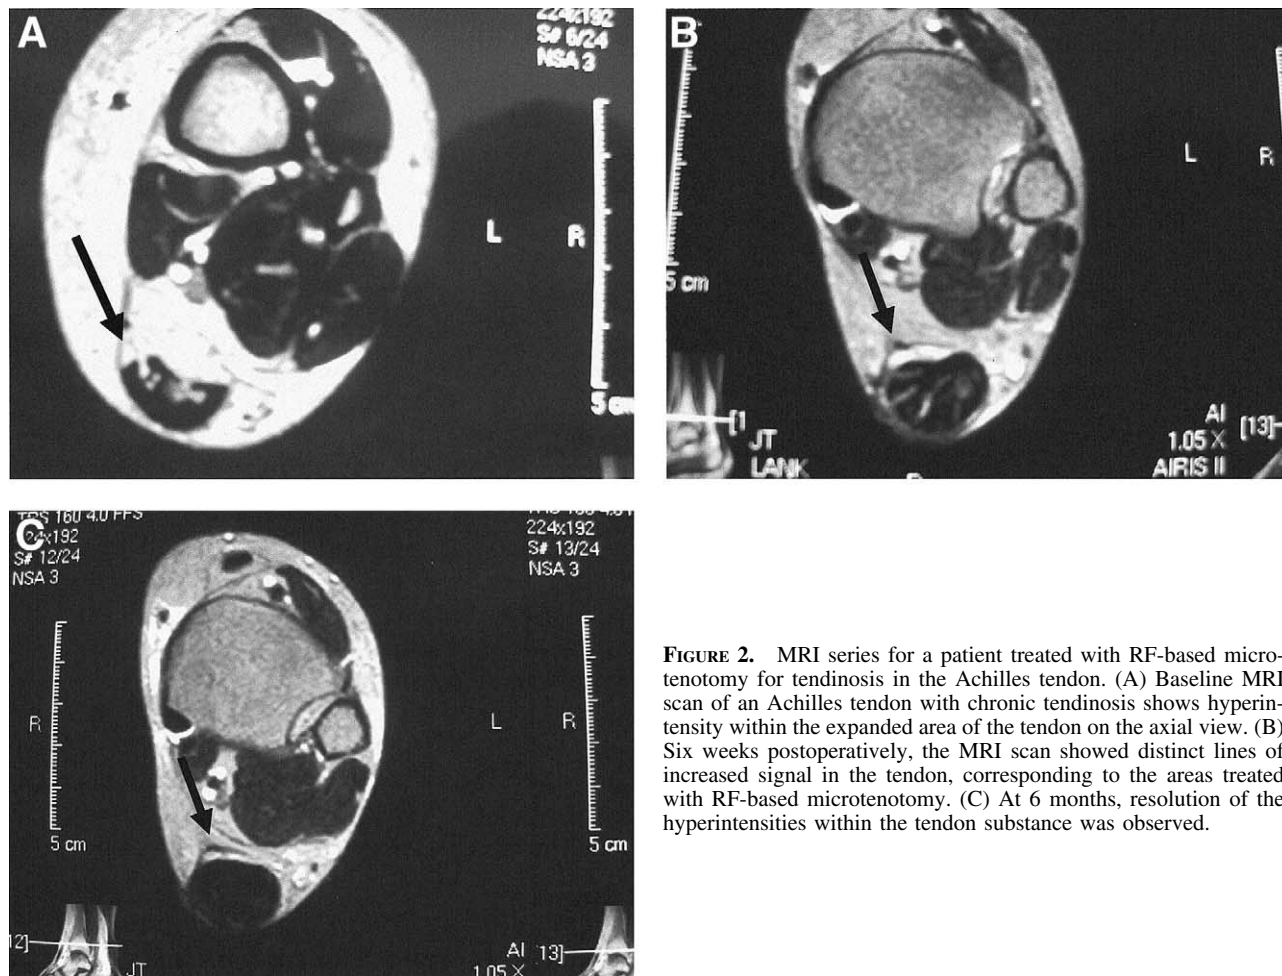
MRI series for a patient treated with RF-based microtenotomy for tendinosis in the Achilles tendon. (A) Baseline MRI scan of an Achilles tendon with chronic tendinosis shows hyperintensity within the expanded area of the tendon on the axial view. (B) Six weeks postoperatively, the MRI scan showed distinct lines of increased signal in the tendon, corresponding to the areas treated with RF-based microtenotomy. (C) At 6 months, resolution of the hyperintensities within the tendon substance was observed.
